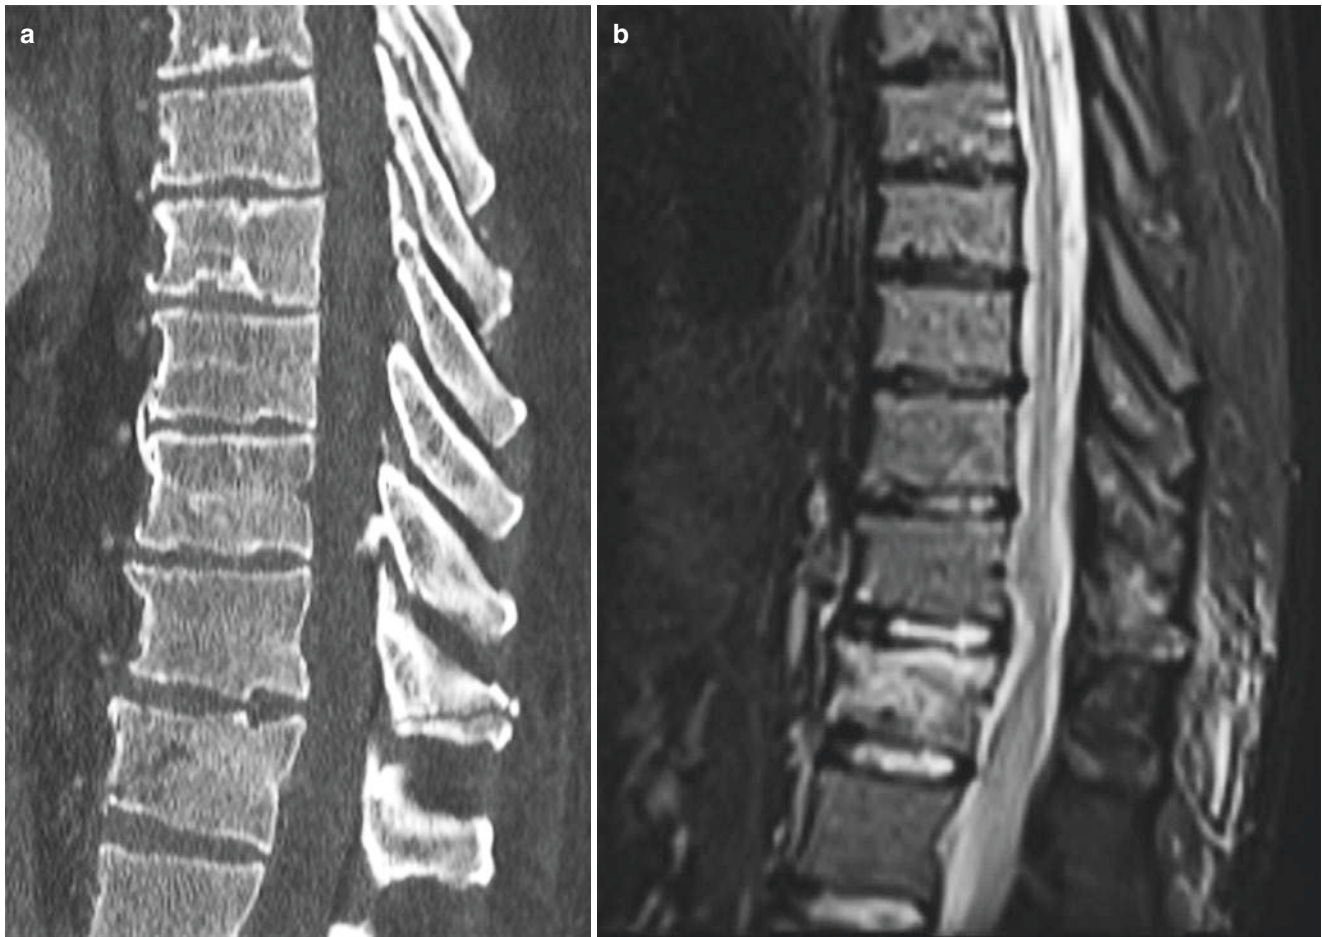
56 year old male who fell 15 ft from a tree stand while deer hunting. (a) Sagittal reformatted CT image reveals compression of a lower thoracic vertebra with fracture lines extending through the anterior and middle columns as well as through the spinous process. (b)
